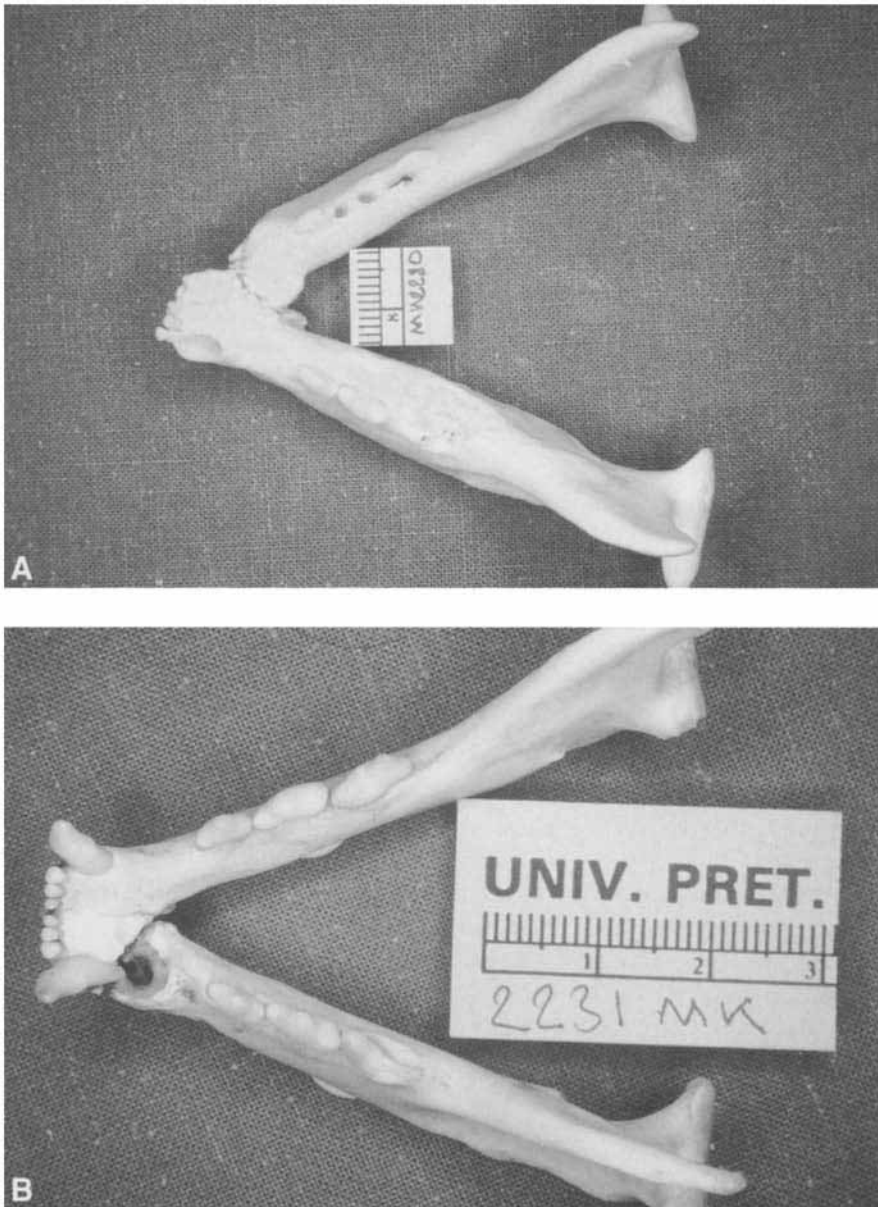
(A) Healing fracture of the body of the right mandible, with loss of the right mandibular incisors and CmandR; root fractures of both M1mand are evident. (B) Pathological fracture of the body of the left mandible, caused by a large periapical lesion associated with a complicated crown fracture of CmandL; a complicated crown-root fracture of M1mandL is also present.
